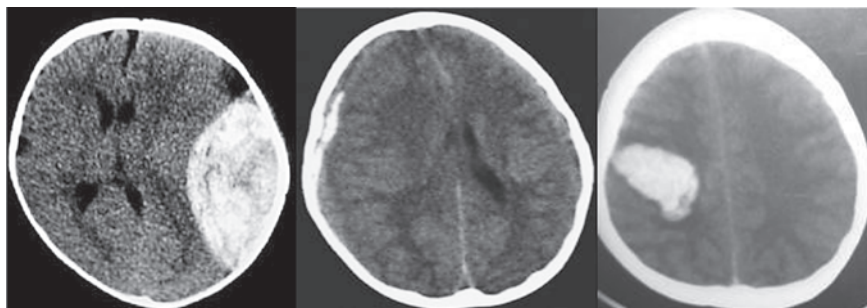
Plain CT showing extradural hemorrhage (biconvex shaped) in the left parietal region with midline shift. b. Plain CT shows subdural hemorrhage (plano convex) in right parietal region with midline shift. c. Plain CT showing intra parenchymal bleed in the right parietal region
